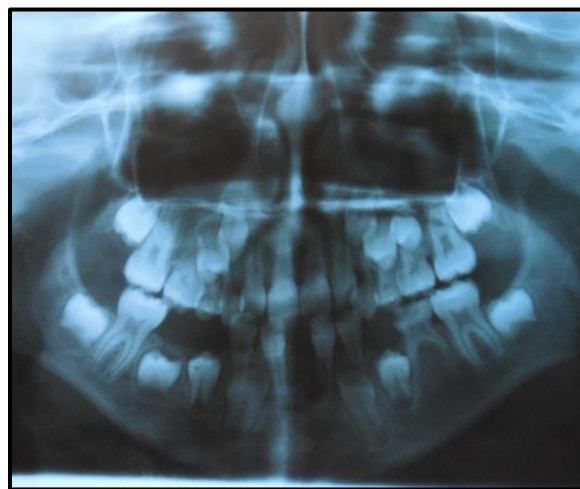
Pre-treatment orthopantomogram showing missing tooth buds of 15, 35, 31 and 41
